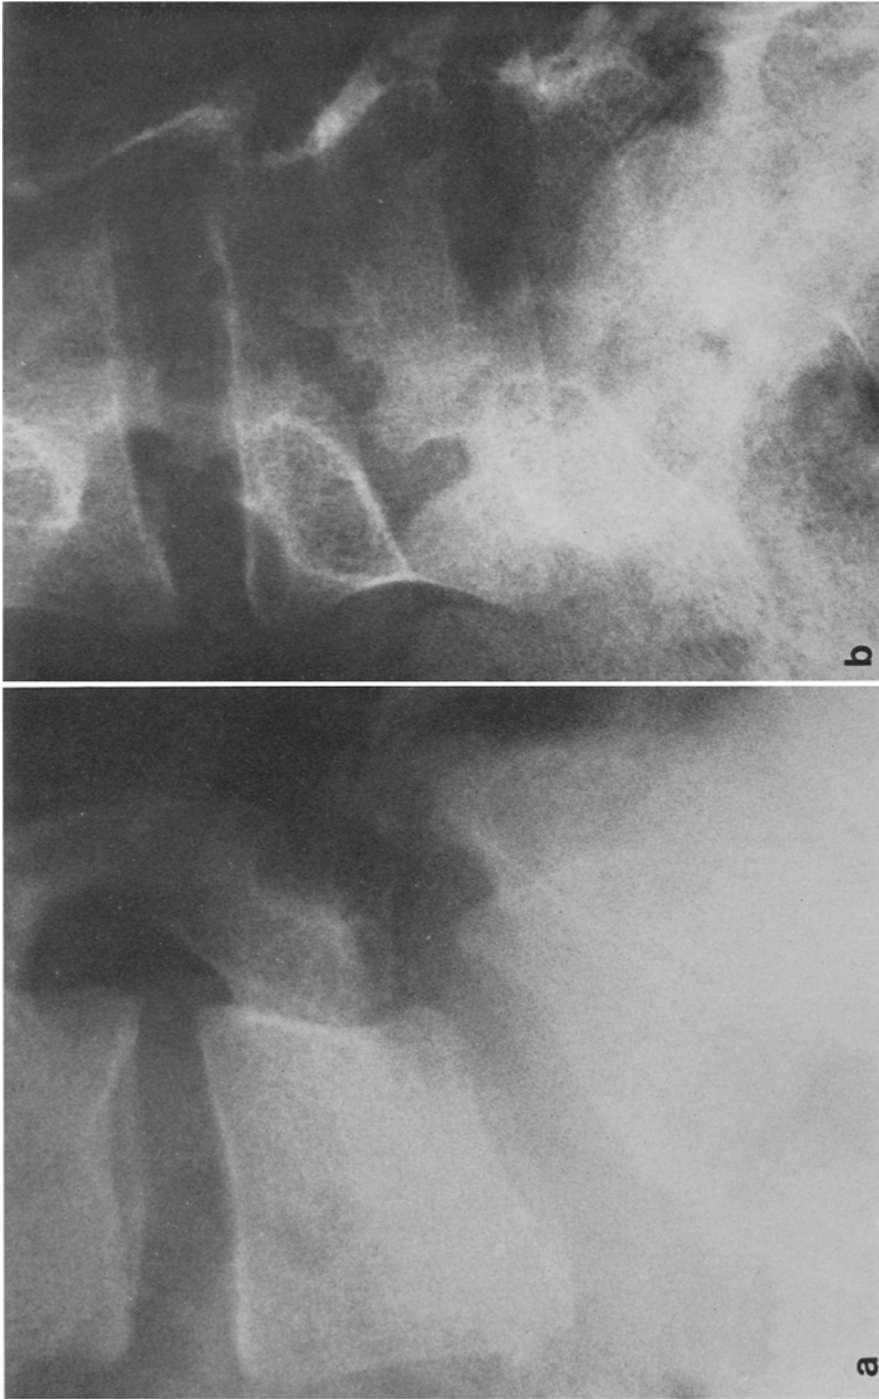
Roentgenograms of the lumbar spine showing spondylolisthesis of the 5th lumbar spine.
